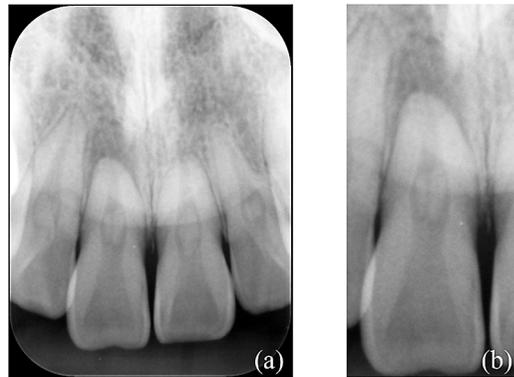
Periapical radiographs obtained at first visit (a) Radiopaque structure was observed in root canal in all four teeth in image field; (b) Close-up view of right maxillary central incisor area.
